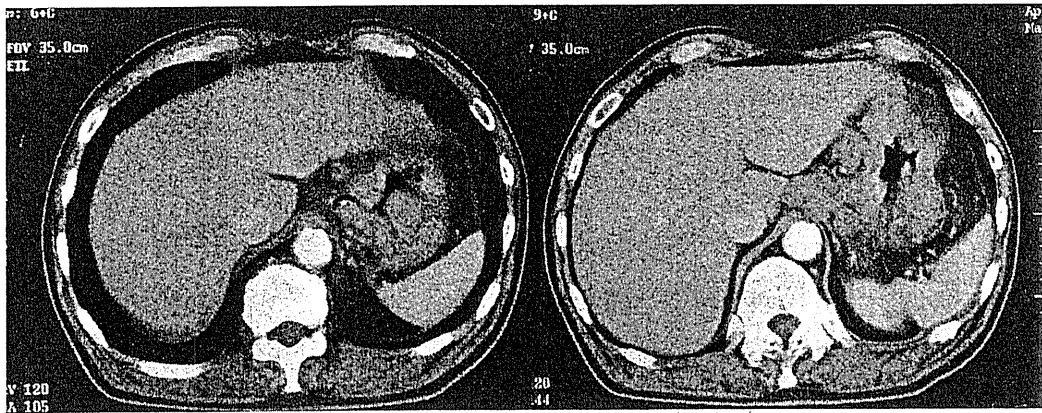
Abdominal CT revealed many enlarged lymph nodes, including para-aortic nodes.
